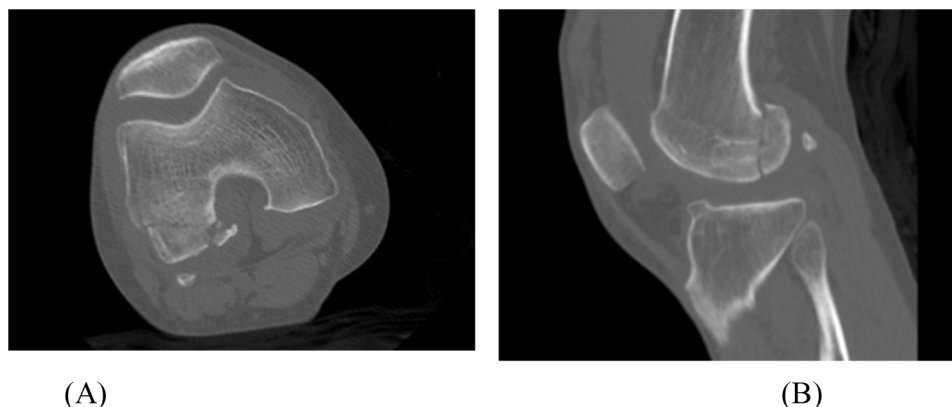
A computed tomography image of the Hoffa fracture with (A) coronal and (B) sagittal planes depicting the lateral fragments.
